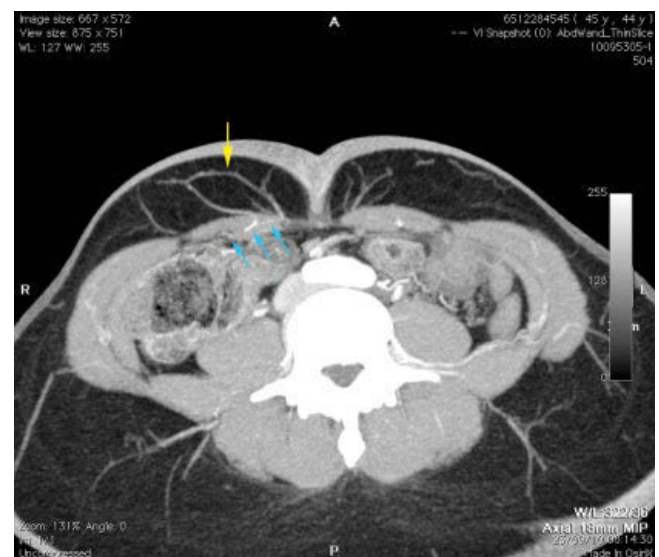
Preoperative CT angio image at the level of the umbilicus showing two important perforators on the right side connecting through a subdermal vascular plexus that drains immediately into the superficial epigastric vein (yellow arrow). The intramuscular course of the branches of the deep inferior epigastric artery can also be seen (blue arrows).
